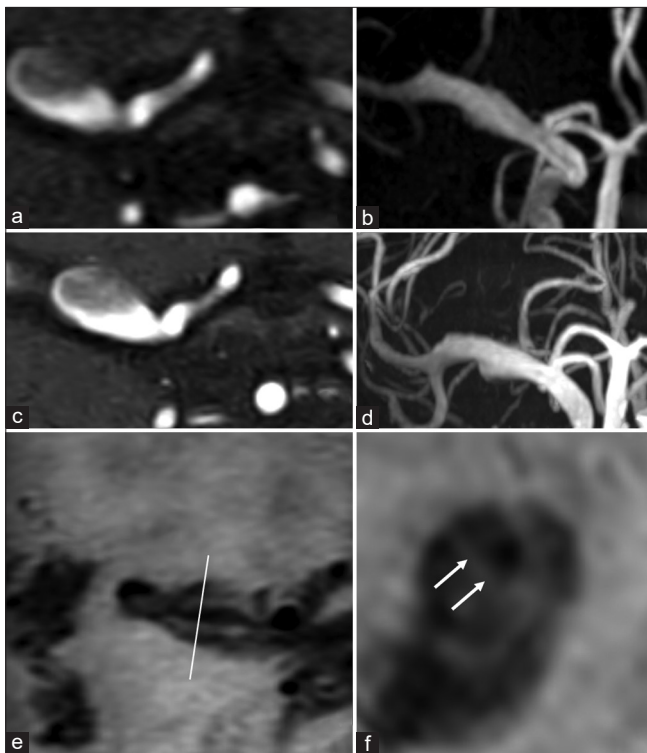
Initial magnetic resonance angiography at presentation. (a) Source imaging, (b) maximum intensity projection showed an enlarged middle cerebral artery, (c, d) 10 days after the onset of the headache, these images showed enlargement of the M1 segment, (e) axial T1-weighted black-blood imaging, and (f) multiplanar imaging showed a double lumen (arrows).
